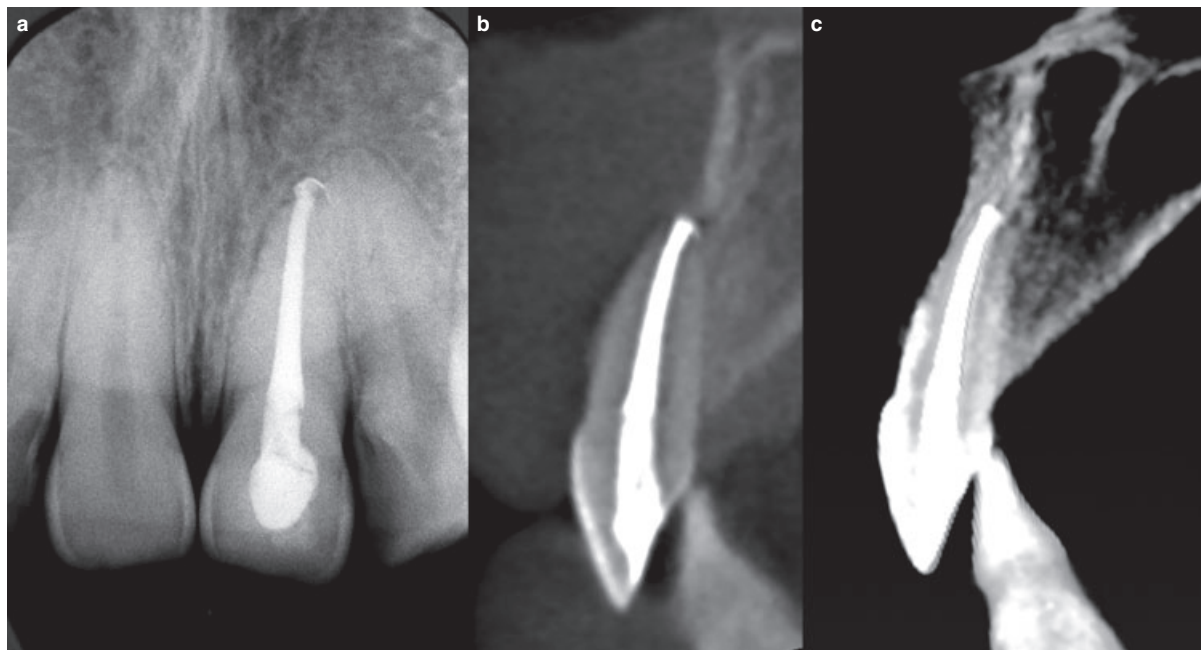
Eleven-month follow-up. (a) The periapical radiograph shows evidence of apical bone remodeling. (b, c) Cross-sectional images demonstrate periradicular normalcy and new buccal cortical bone formation apical to the maxillary left central incisor.
